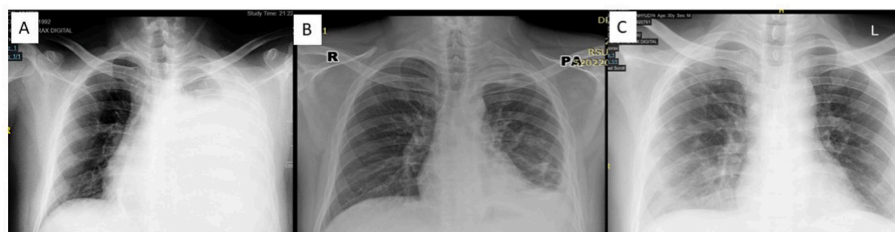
Chest X-Ray: A. 17 February 2022, B. 19 May 2022 (after Pleurodesis, Pembrolizumab + Lenvatinib), C. 11 February 2023.
